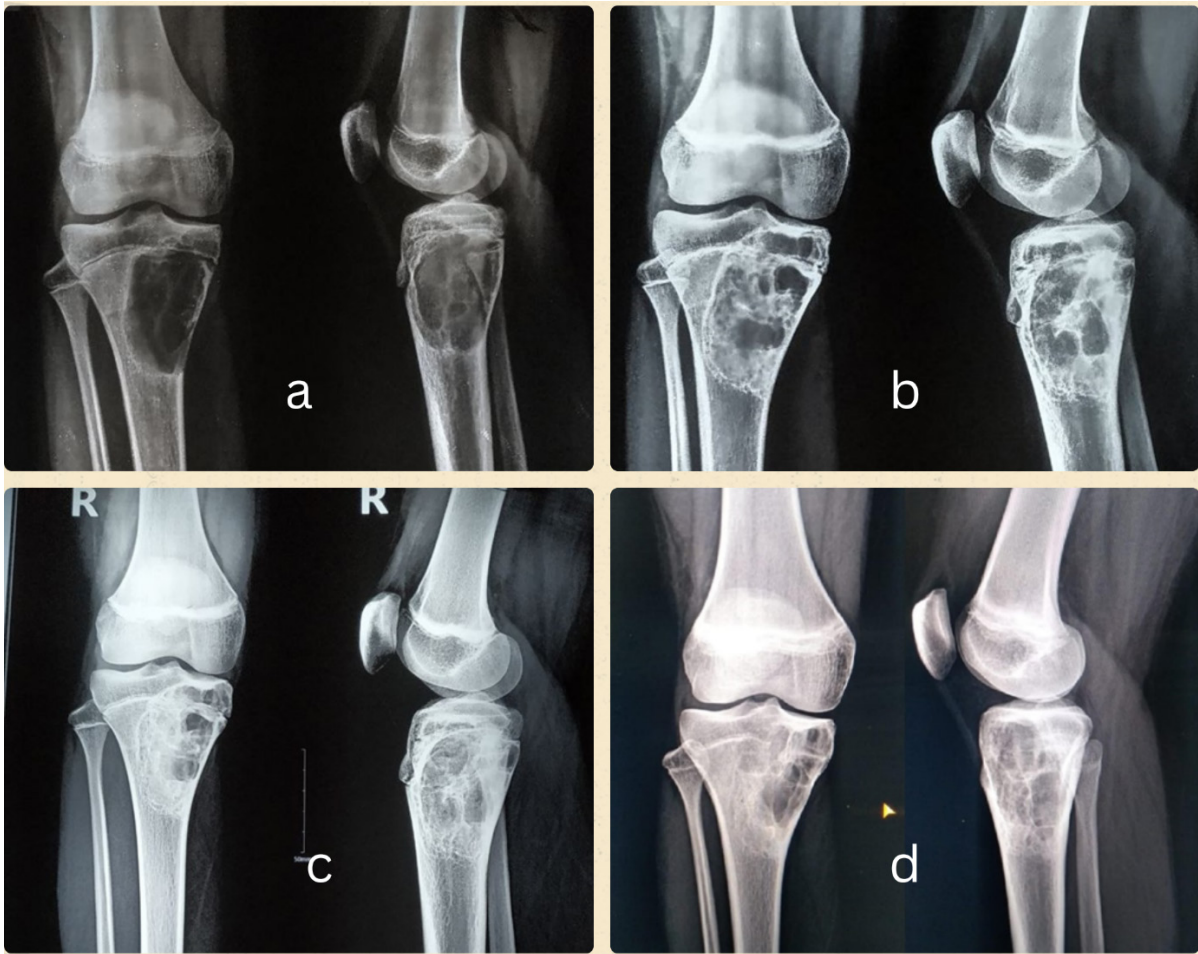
Radiographs showing an ABC affecting the right proximal tibia metaphysis with epiphyseal extension in an 11-year-old female child: (a) before treatment, (b) after first polidocanol injection, (c) after second polidocanol injection at completion of treatment, (d) at 36 months after sclerotherapy
